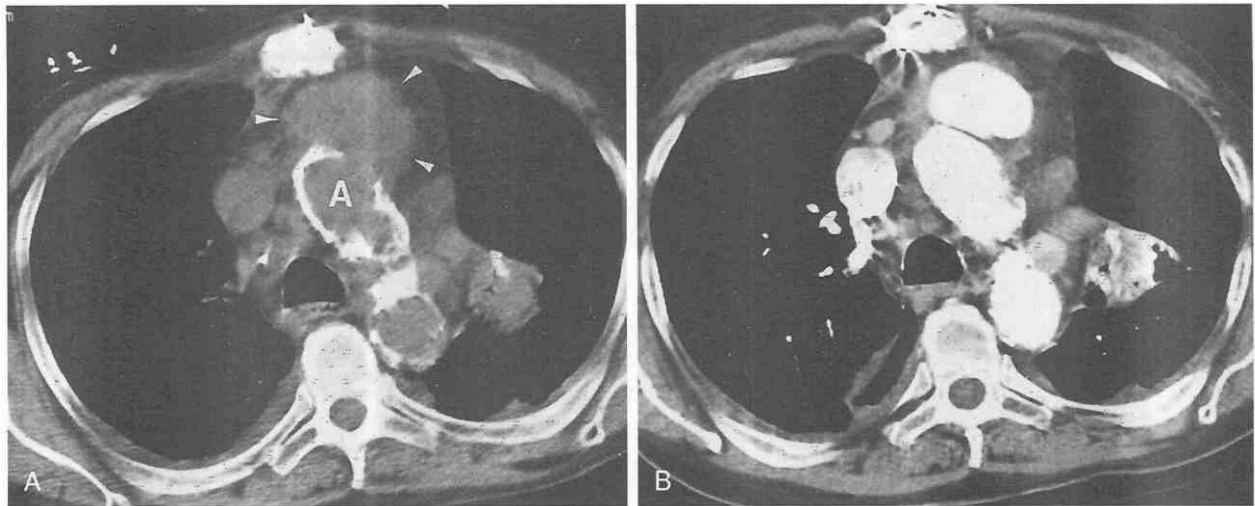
Aortic pseudoaneurysm after coronary artery bypass graft surgery. *A*, Non-contrast-enhanced CT performed 4 weeks after surgery to exclude mediastinitis shows heterogeneous low-attenuation mass in anterior mediastinum (*arrowheads*), suggestive of abscess. *A*, aorta. *B*, Because of the proximity of the mass to the aorta, the patient was rescanned using intravenous contrast, and the mass was shown to be a pseudoaneurysm arising from the aortic cannulation site.
